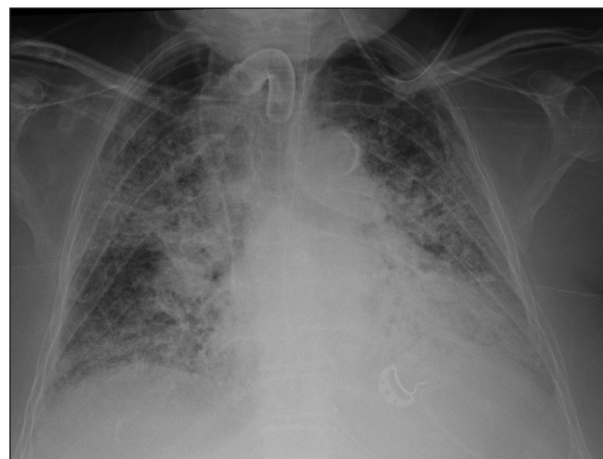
Chest X-ray — infiltrate in the right lower lung and one in left lower lung
